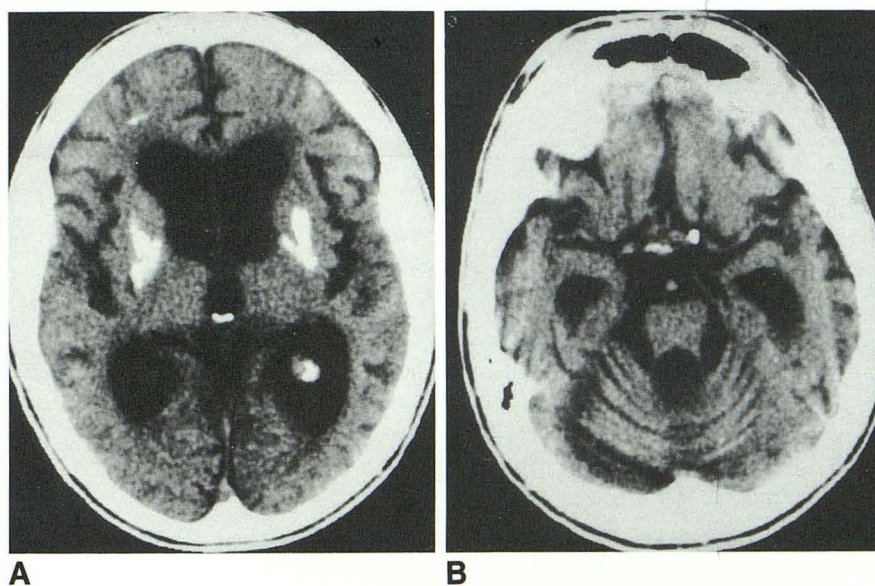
Kearns-Sayre syndrome; 25-year-old man with long history of muscle weakness, cardiac conduction block, and external ophthalmoplegia. *A*, and *B*, Axial CT; there is marked cerebral, cerebellar, and brain stem atrophy with heavy calcification in the lentiform nuclei and faint calcification in the right frontal white matter.
